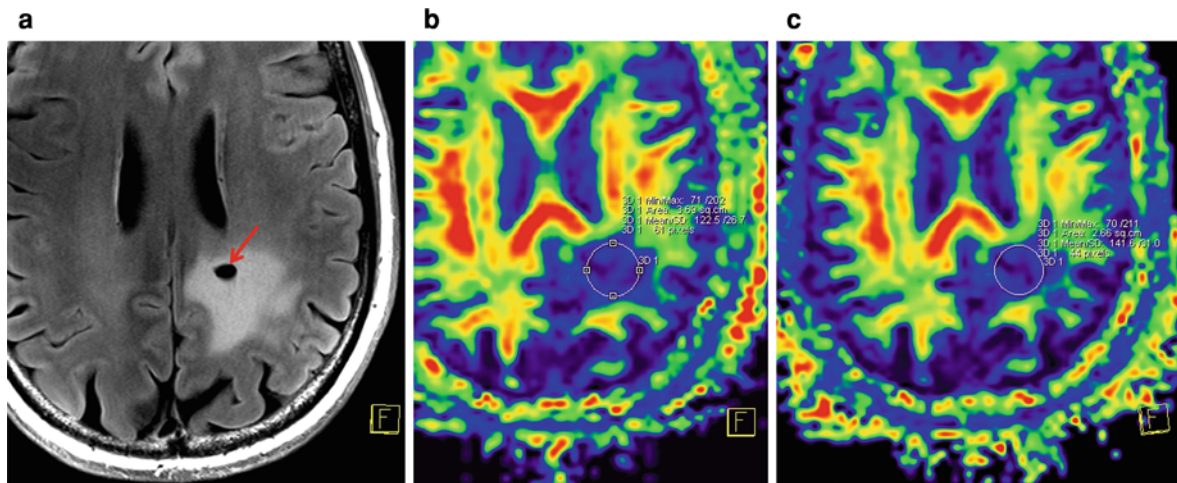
The FLAIR sequence (a, 7 T, TR 12,000, TE 83, TI 2,760 ms, matrix 512×298 , FoV 230×179 mm, slice thickness 2 mm) shows the extent of a low-grade astrocytoma with a defect from biopsy (*arrow*). DWI at both 3 T (b, TR 6,400, TE 91 ms, matrix 96×96 , FoV 240×240 mm, slice
